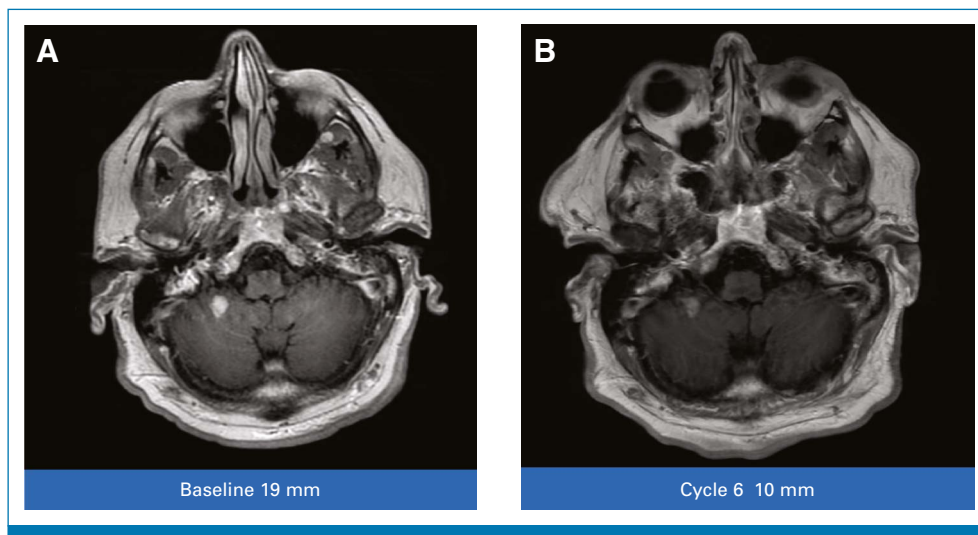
Intracranial response in EGFR ex20ins NSCLC patient. MRI with gadolinium enhancement (A) before and (B) after treatment with zipaleritinib. EGFR, epidermal growth factor receptor; ex20ins, insertions in EGFR exon 20; NSCLC, non-small-cell lung cancer.
